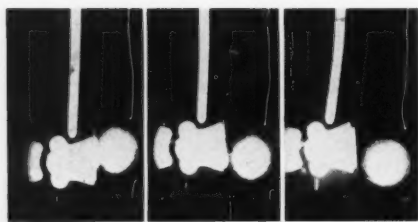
Ultra short radiographic exposures* (one microsecond in duration) showing the impact of golf club and ball. Available through the kindness of Dr. Charles M. Slack, Westinghouse Corporation.
